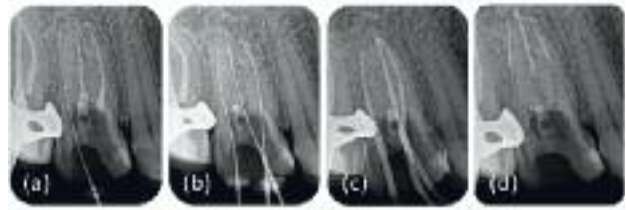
(a-d) Periapical radiographs showing the entire sequence of the non-surgical treatment.
